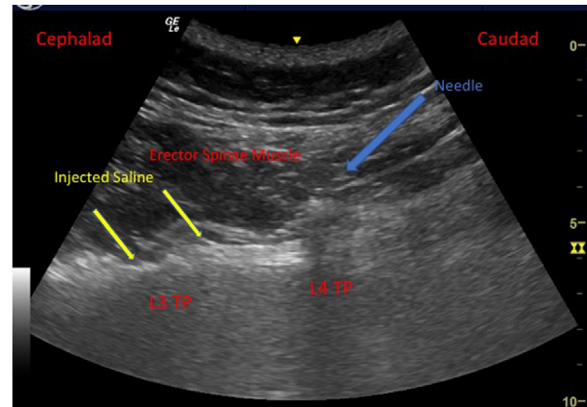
An ultrasound image of erector spinae plane block.
